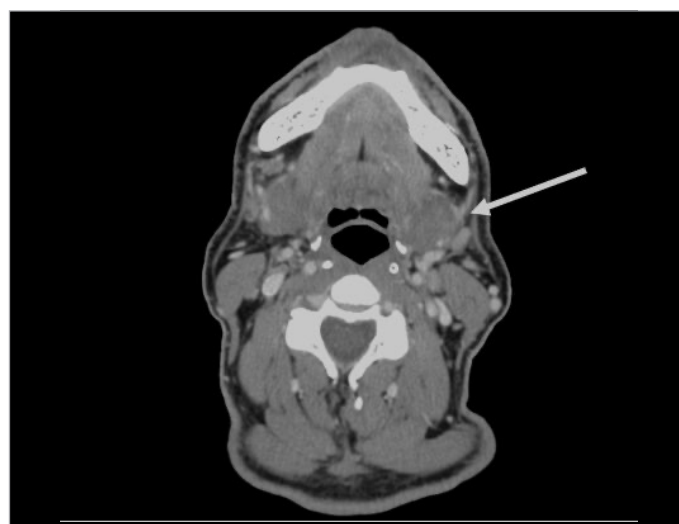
Contrast-enhanced CT scan of the neck showing moderate diffuse enlargement of both submandibular glands without evidence of collections.
